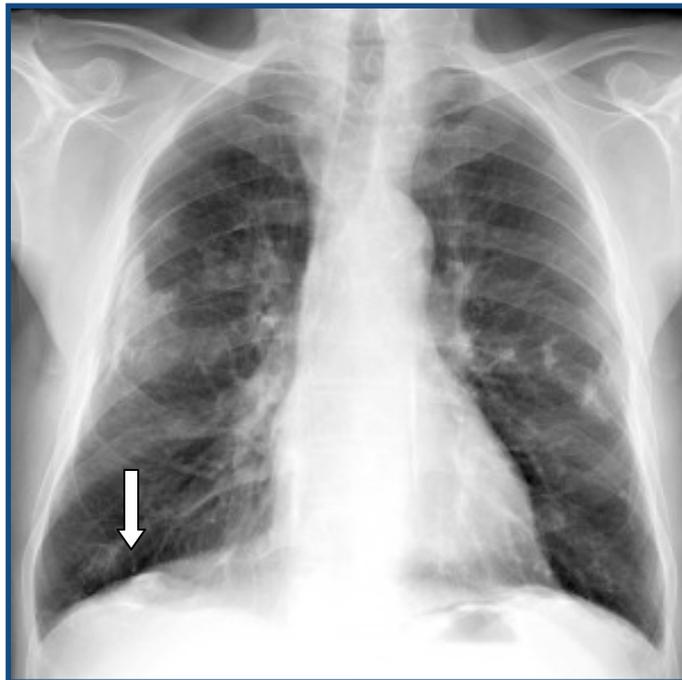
Chest x-ray showing asbestos plaques and pleural calcifications (arrow).
